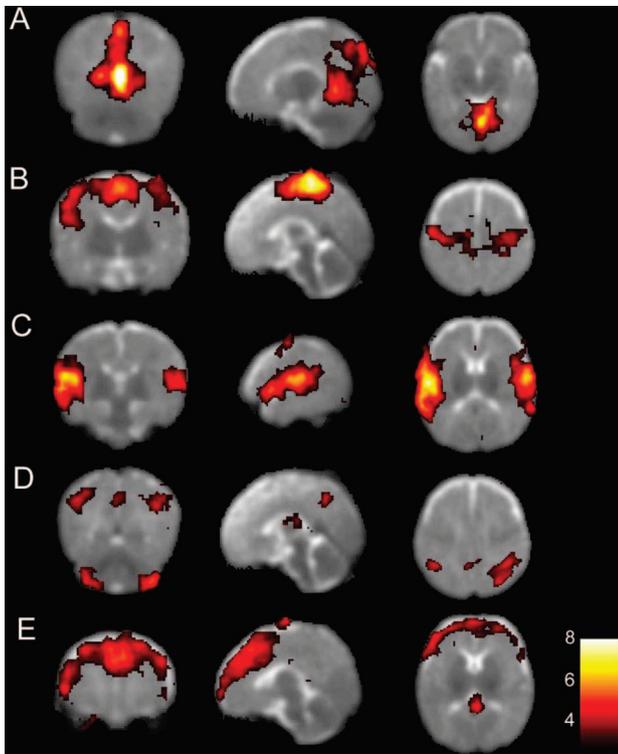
Functional MRI used to map the resting state activity of the brain of lightly sedated preterm infants born before 27 gestational week and scanned at term age around 40 gestational weeks. Several unique resting-states networks are revealed that encompass: (A) Primary visual areas; (B) Somatosensory areas and motor cortices; (C) Temporal areas including primary auditory cortex; (D) Parts of parietal cortex; (E) Medial and lateral sections of the anterior prefrontal cortex. Reprinted from Fransson *et al.*, Proc Natl Acad Sci USA 104:15531–15536, Copyright © 2007 The National Academy of Sciences of the USA, with permission.
